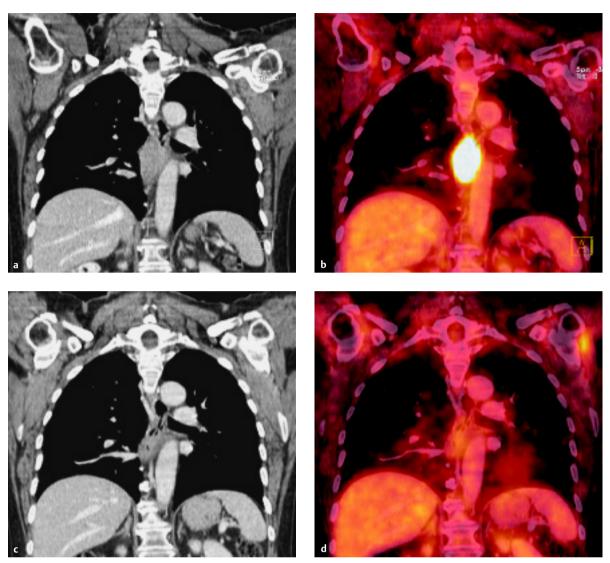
a-d Squamous cell carcinoma of the middle third of the esophagus in a 63-year-old man (stage: uT3, N-positive). Follow-up study. CT (a, c) and FDG PET-CT (b, d) before treatment and after completion of the first cycle of neoadjuvant chemotherapy (cisplatin/5-FU). The SUV was reduced from 22.5 (b) to 4.8 (d). Final stage after esophageal resection: ypT0N0.
